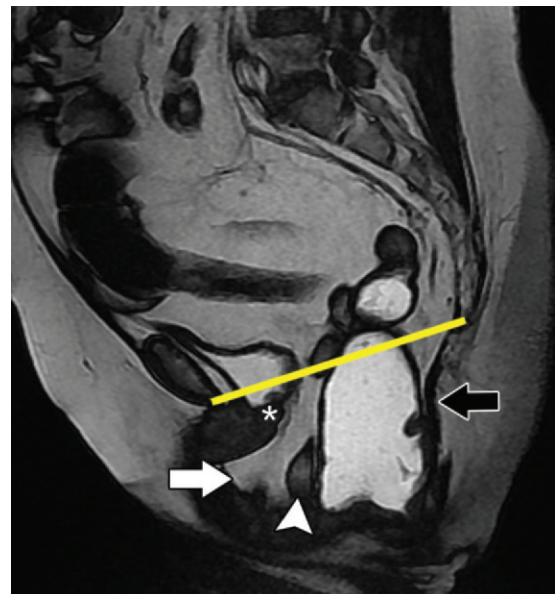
Peritoneocele and enterocele in a 63-year-old woman with a bulging perineal mass and a history of hysterectomy. Sagittal FIESTA MR image obtained at maximal effort during defecation shows herniation of mesenteric fat (white arrow) and small intestine (arrowhead) into the rectovaginal space. In the anterior compartment, no substantial cystocele is seen in relation to the PCL (yellow line). In the middle compartment, an apical prolapse (*) and horizontal angulation of the vagina are depicted. Note the caudal angulation of the levator plate (black arrow) and the descent of the anorectal junction, features indicative of pelvic floor relaxation.
